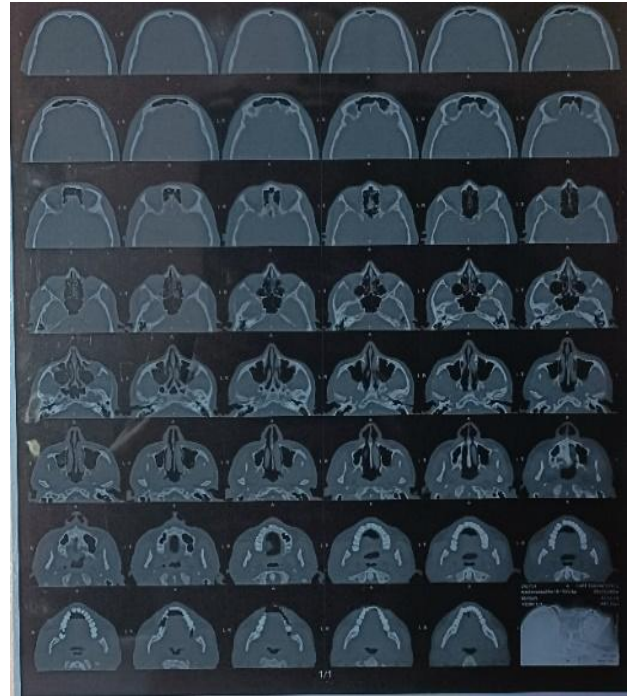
Results of x-ray.
